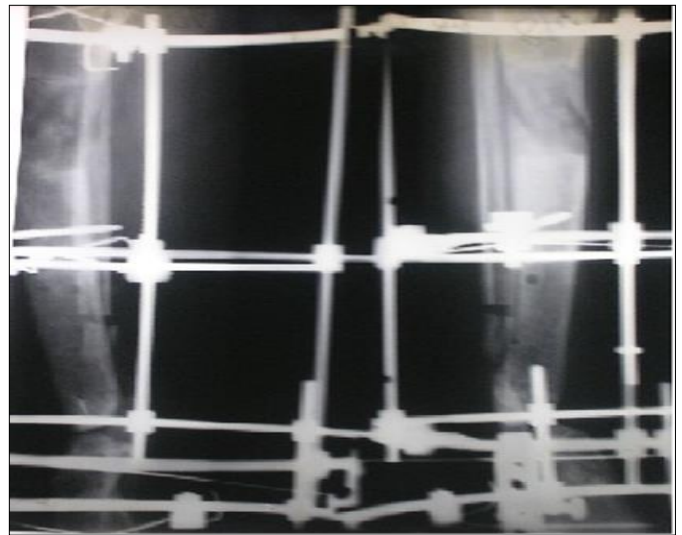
X-ray showing completion of transport with regenerate.
